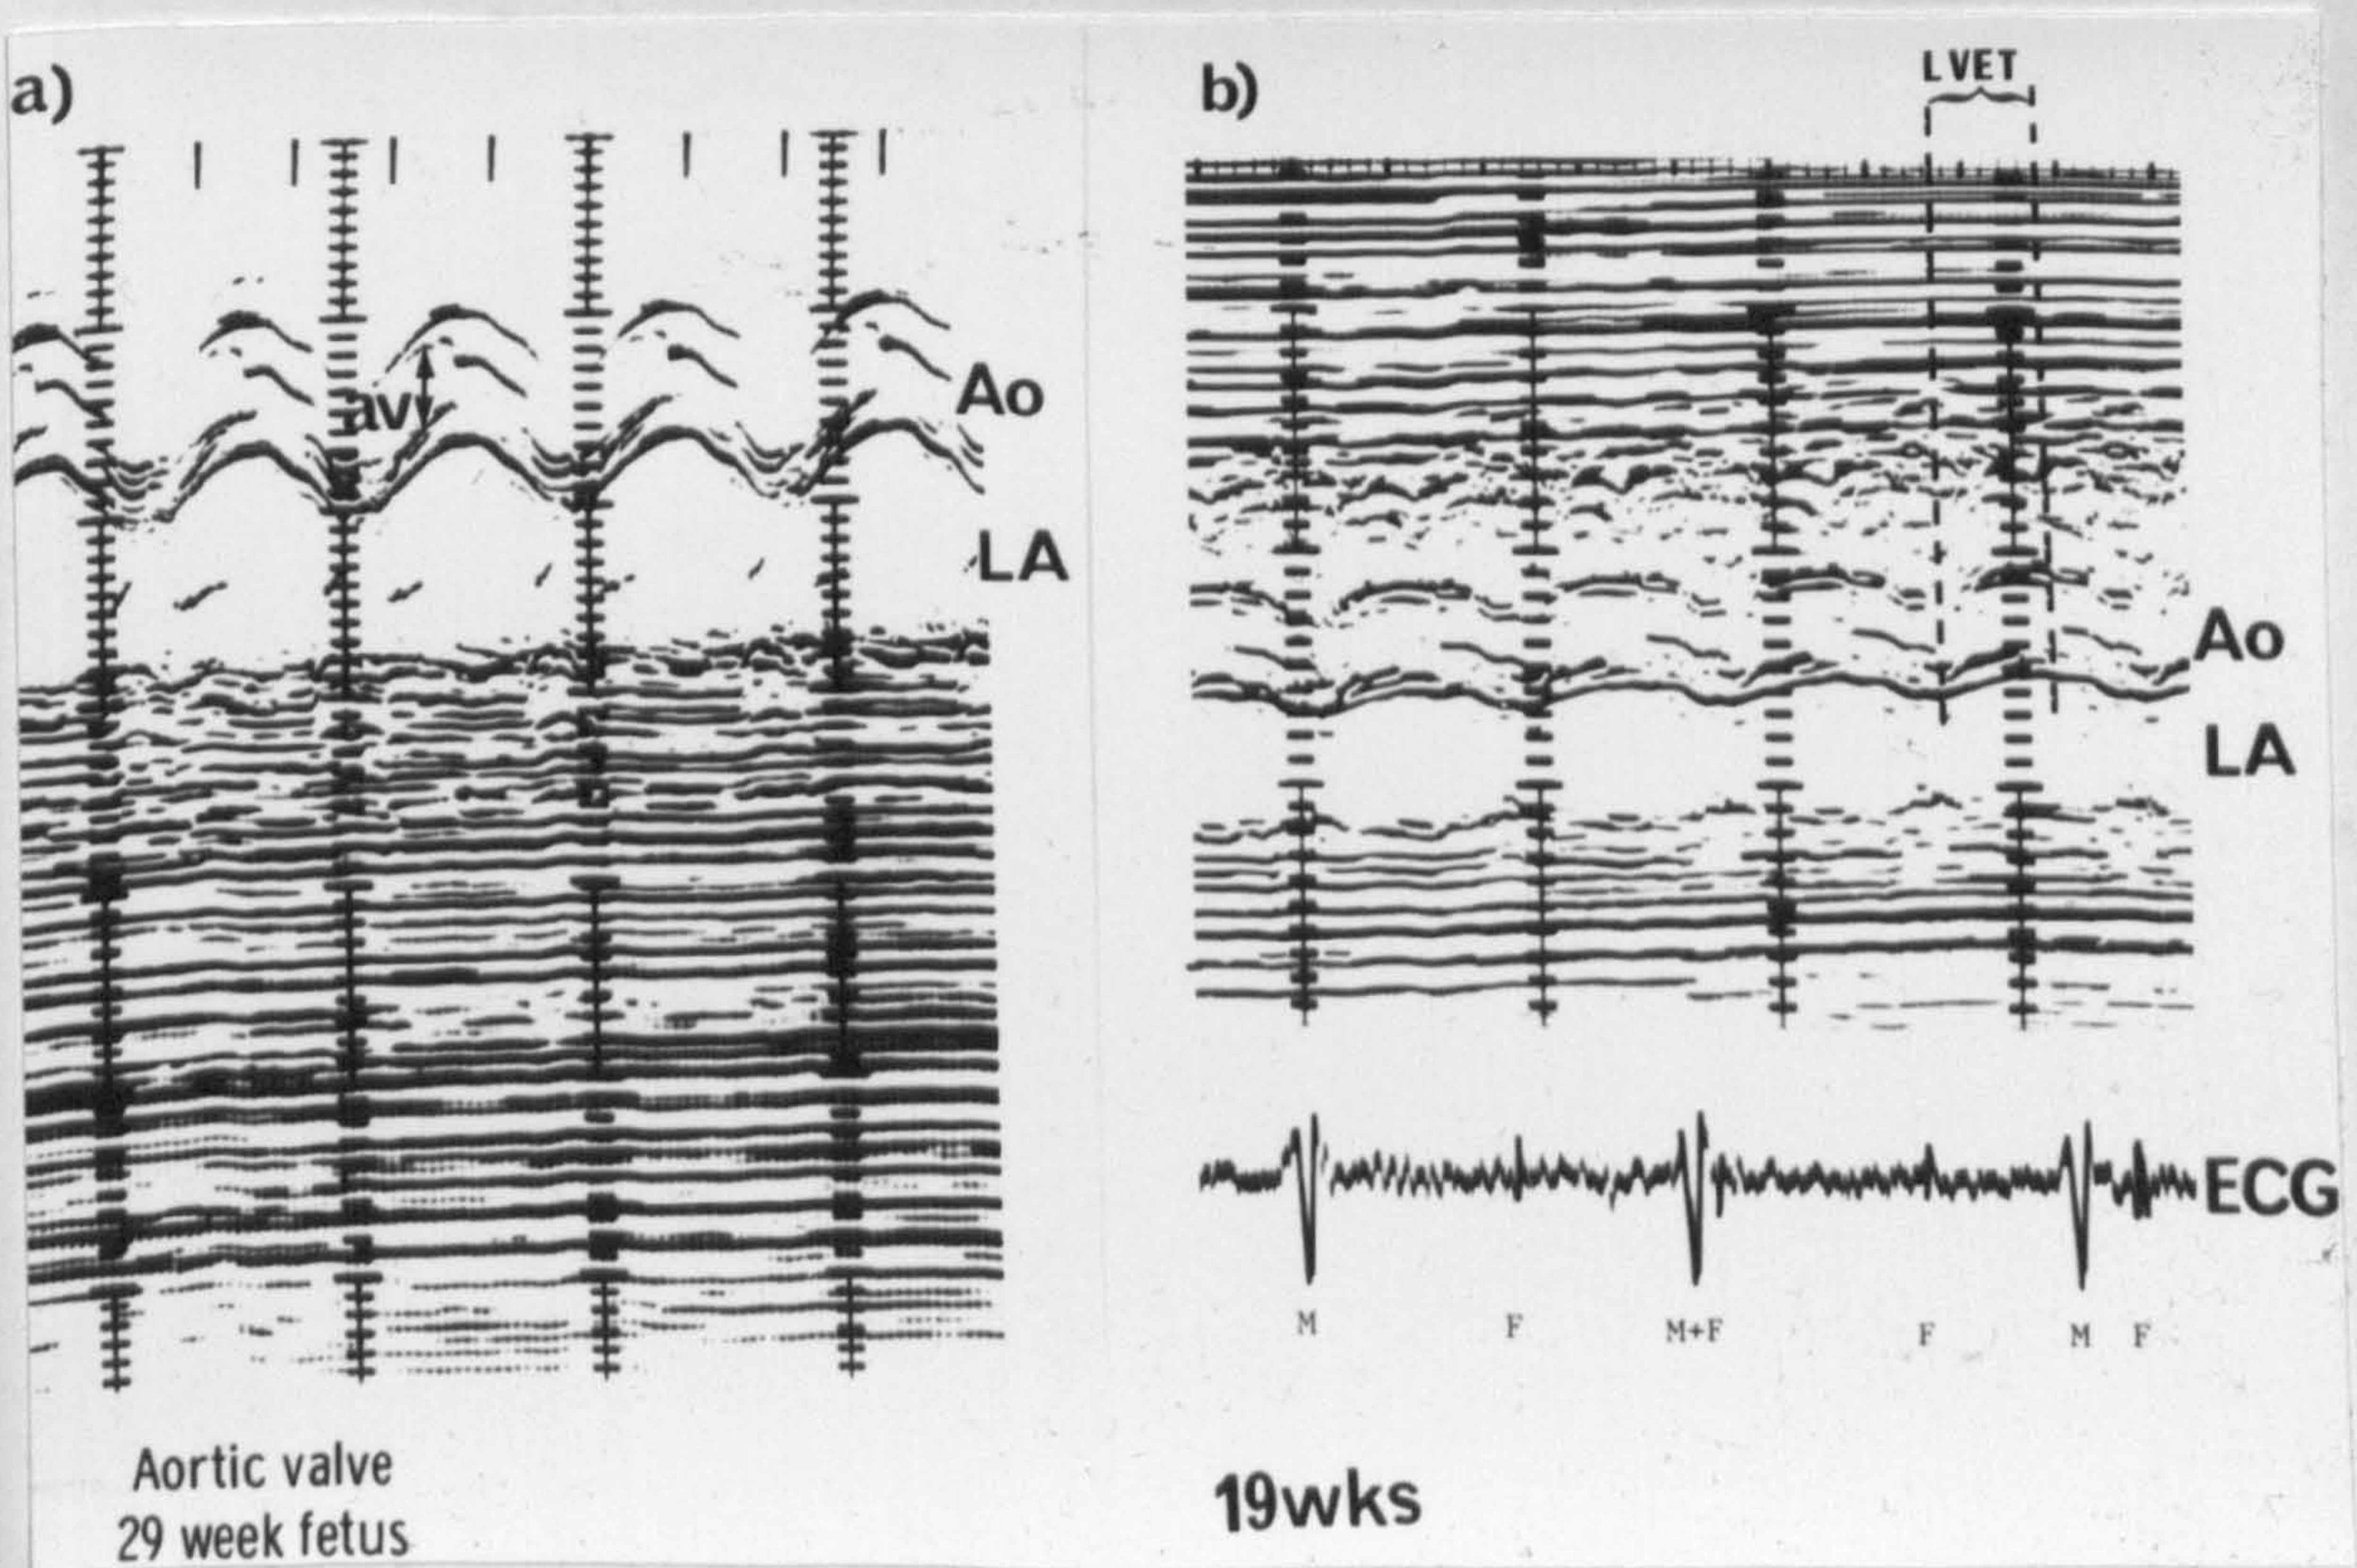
(a) M mode echocardiogram of the aortic valve with the left atrium posterior.
